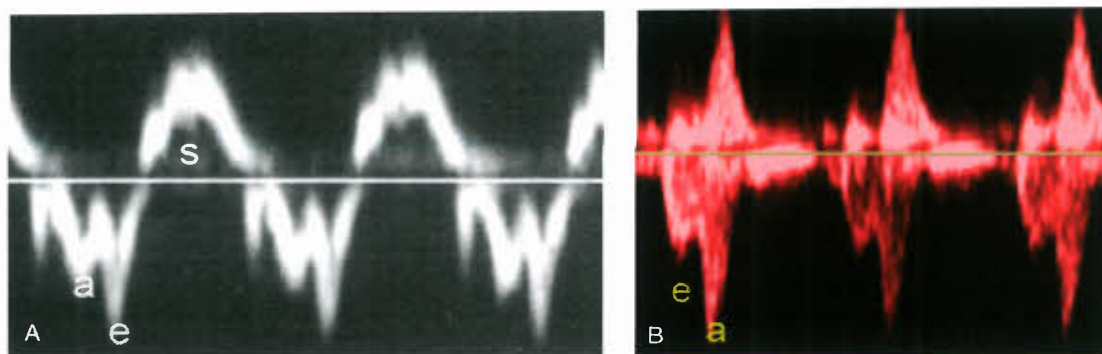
Doppler tissue imaging velocities from lateral tricuspid valve ring (A) and Doppler flow-velocity waveforms from right ventricular inflow of normal midtrimester fetus (B). Note dominant a' and a waves. These waveforms are consistent with relatively restrictive fetal ventricular myocardium at this stage of development.
